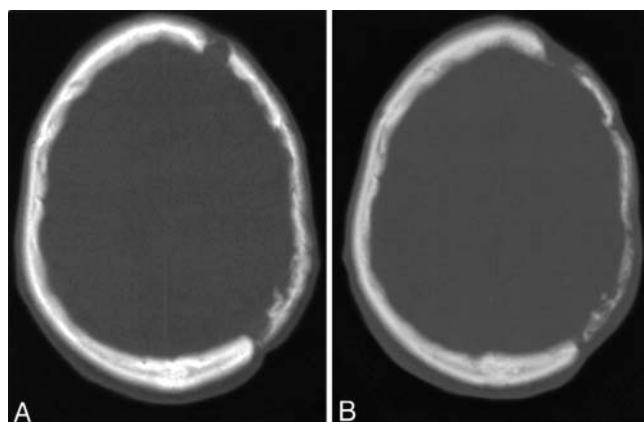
Axial CT scans revealing progressive bone resorption over a 5-month period.
